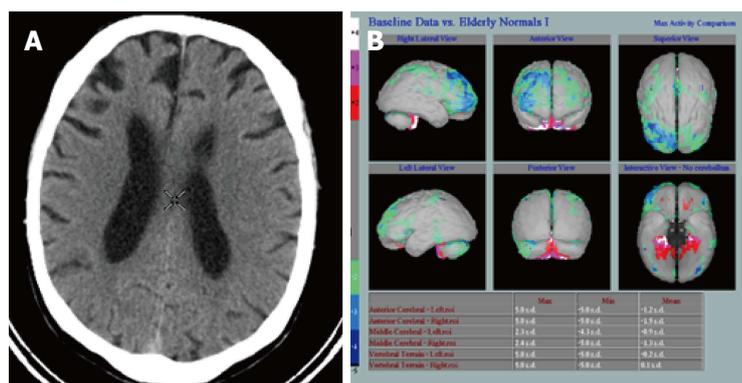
Computed tomography showing atrophy. A: Asymmetric right frontal lobe atrophy in fronto-temporal dementia; B: Hexamethylpropylene amine oxime single photon emission computed tomography in the same patient (Images kindly prepared by Ms Lewley Lovell, and Dr. Fergus Mckiddie).
